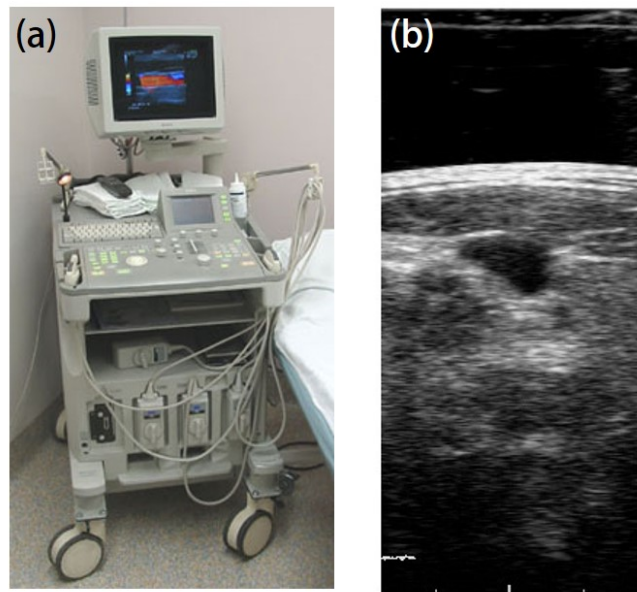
Ultrasound: (a) outer appearance of Ultrasound (US) machine [148]; (b) US image of the internal jugular vein measurement of a normal male.
